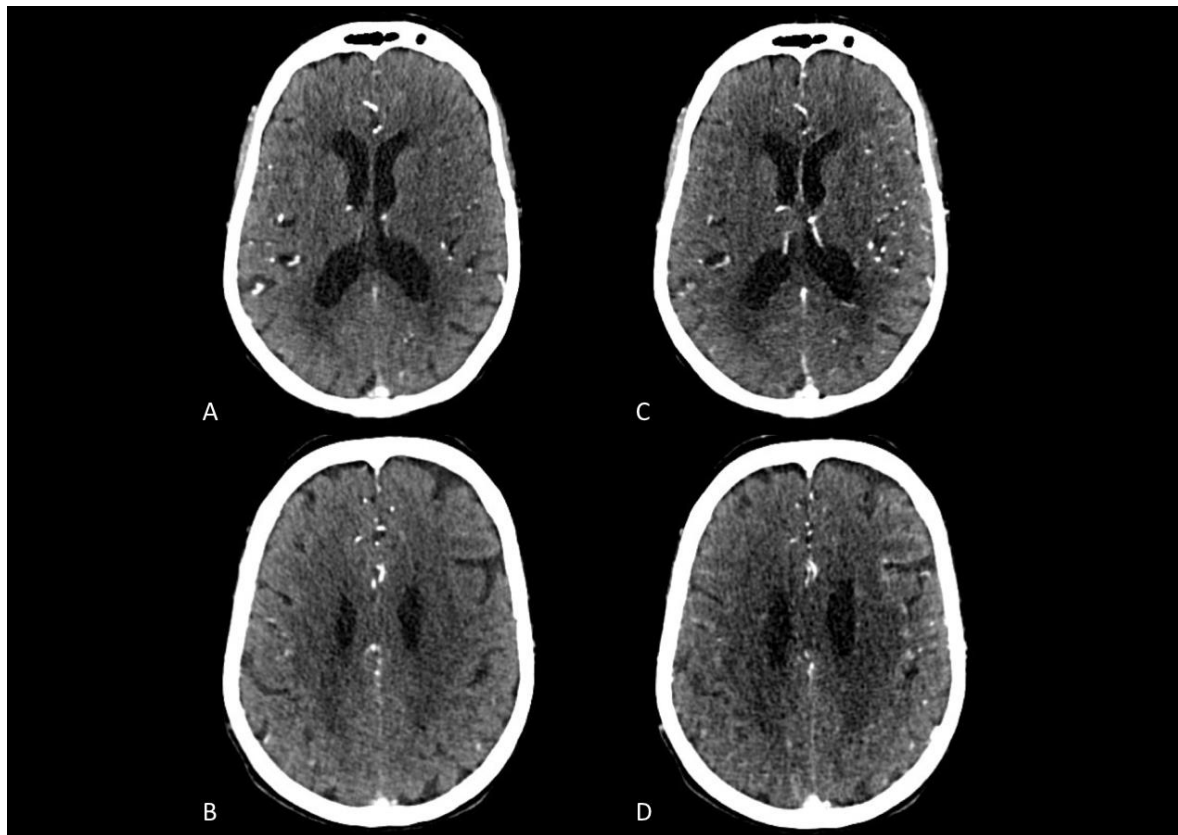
Occlusion in M1 segment of the left middle cerebral artery. A & B) Correspond to the arterial phase. C & D) Correspond to the delayed phase with filling by leptomeningeal vessels in the M1-M2-M4 and M5 region of ASPECTS. Considering a significant mismatch, the patient underwent mechanical thrombectomy.
